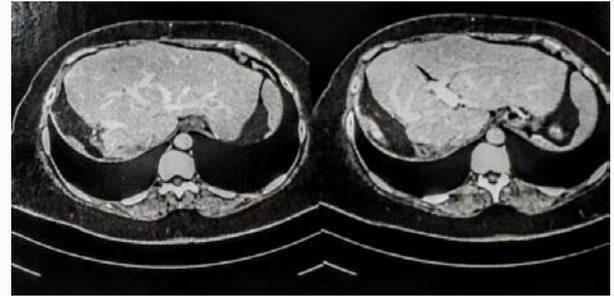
CT after one year of intervention - Open right hepatectomy.
